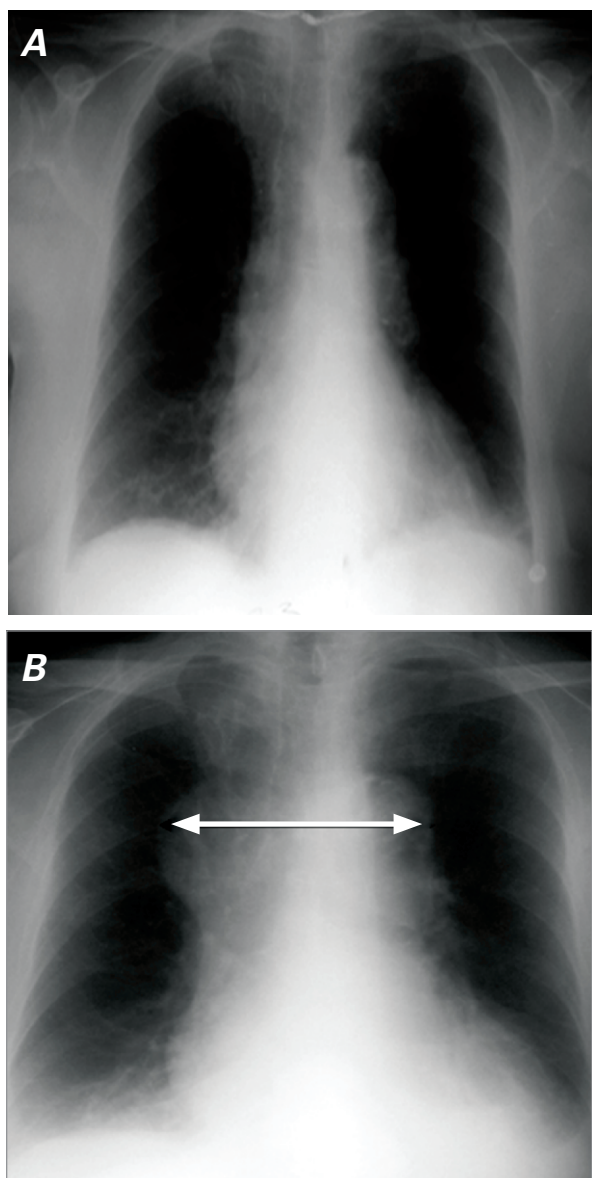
Patient 2. Chest radiographs show A) a normal appearance on admission and B) a significantly widened mediastinum (arrow).
